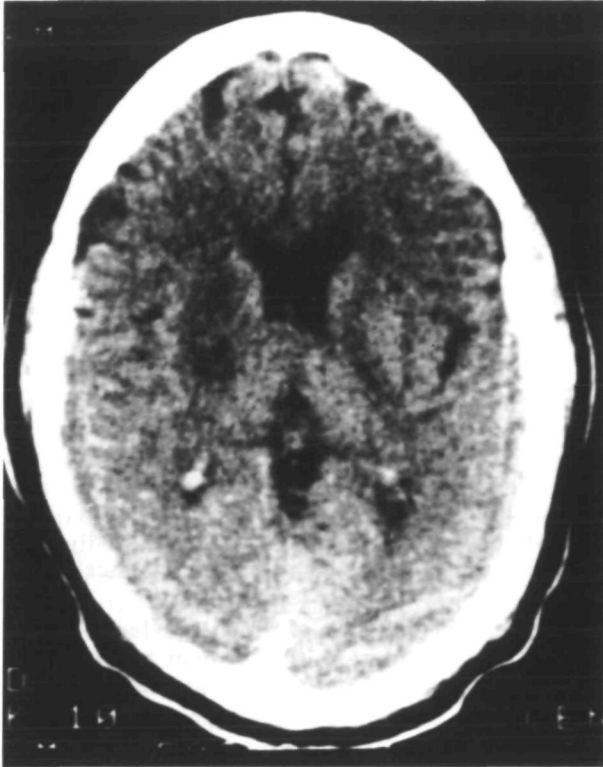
Unenhanced computed tomographic scan of the brain in case 1 on day 7.
